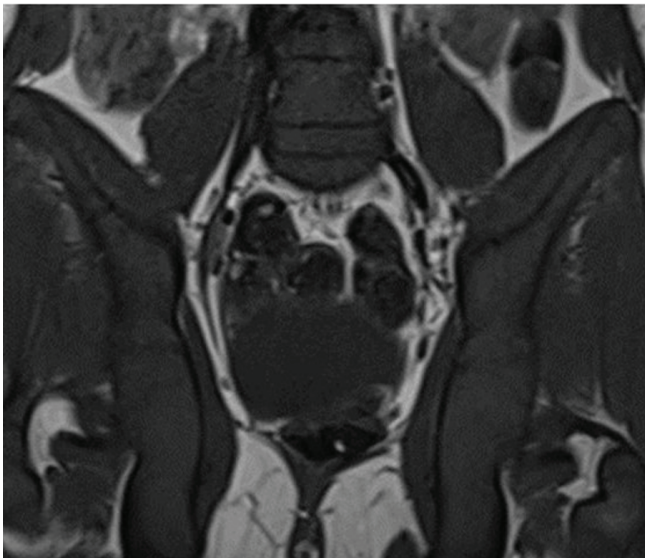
Coronal T1-weighted image of a nine-year-old male patient diagnosed with acute lymphocytic leukemia, showing a markedly decreased T1 signal secondary to the diffuse infiltration of the bone marrow
